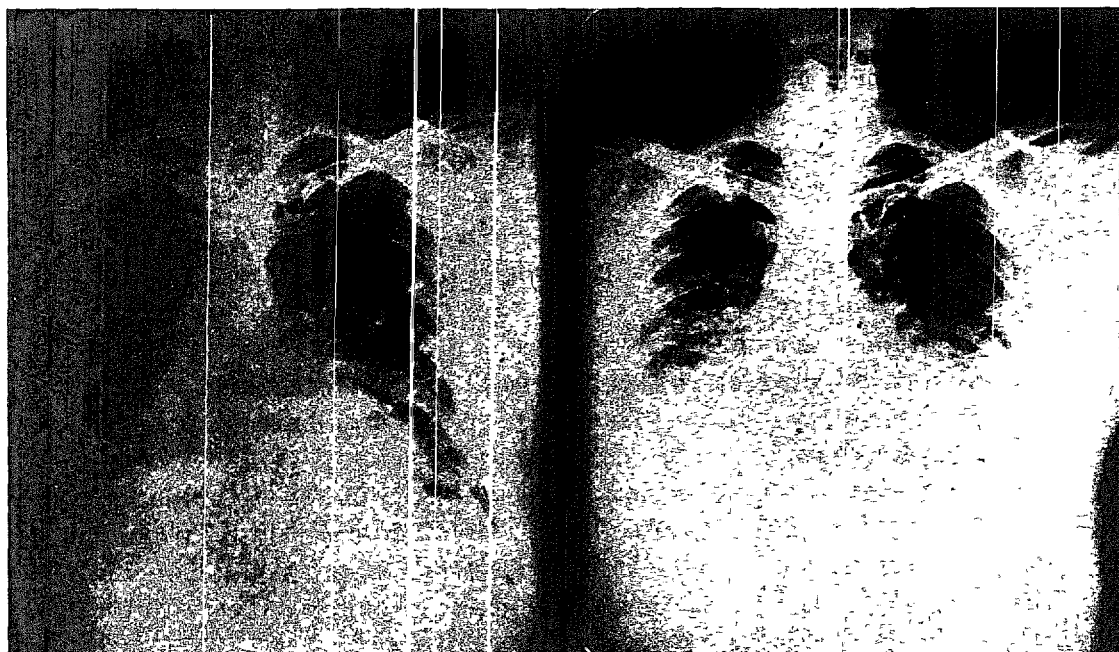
Inspiratory and expiratory X-ray (H. R.)
